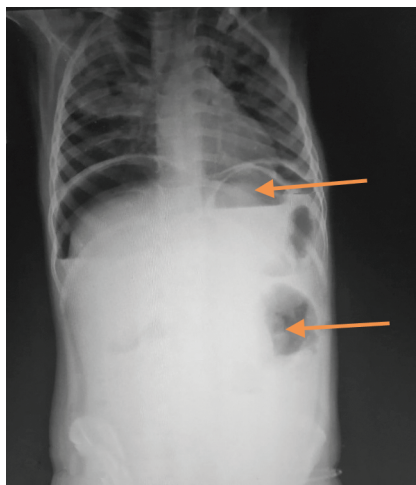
Chest X-ray showing infiltrates in right para-cardiac region with air fluid level in abdomen
